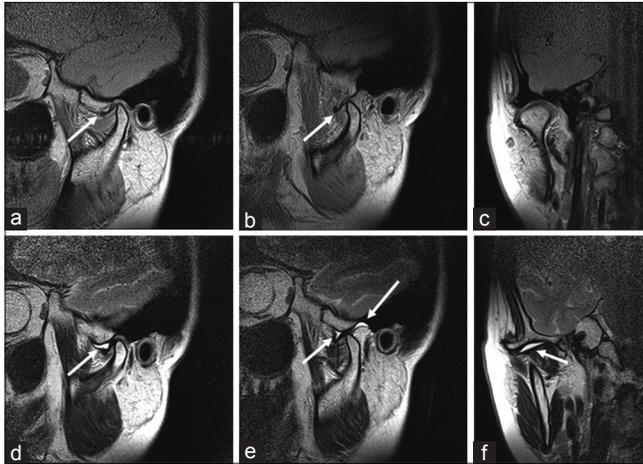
Magnetic resonance imaging of the right temporomandibular joint in a 28-year-old female with temporomandibular disorders. (a and c) Proton density-weighted sagittal and coronal oblique cross section imaging at the closed mouth position (arrow: Disc displacement). (b) Proton density-weighted sagittal oblique cross-section imaging at the maximum mouth opening position. (d and f) T2-weighted sagittal and coronal oblique cross-section imaging at the closed mouth position (arrow: Temporomandibular joint effusion). (e) T2-weighted sagittal oblique cross-section imaging at the maximum mouth opening position (arrow: Temporomandibular joint effusion)
